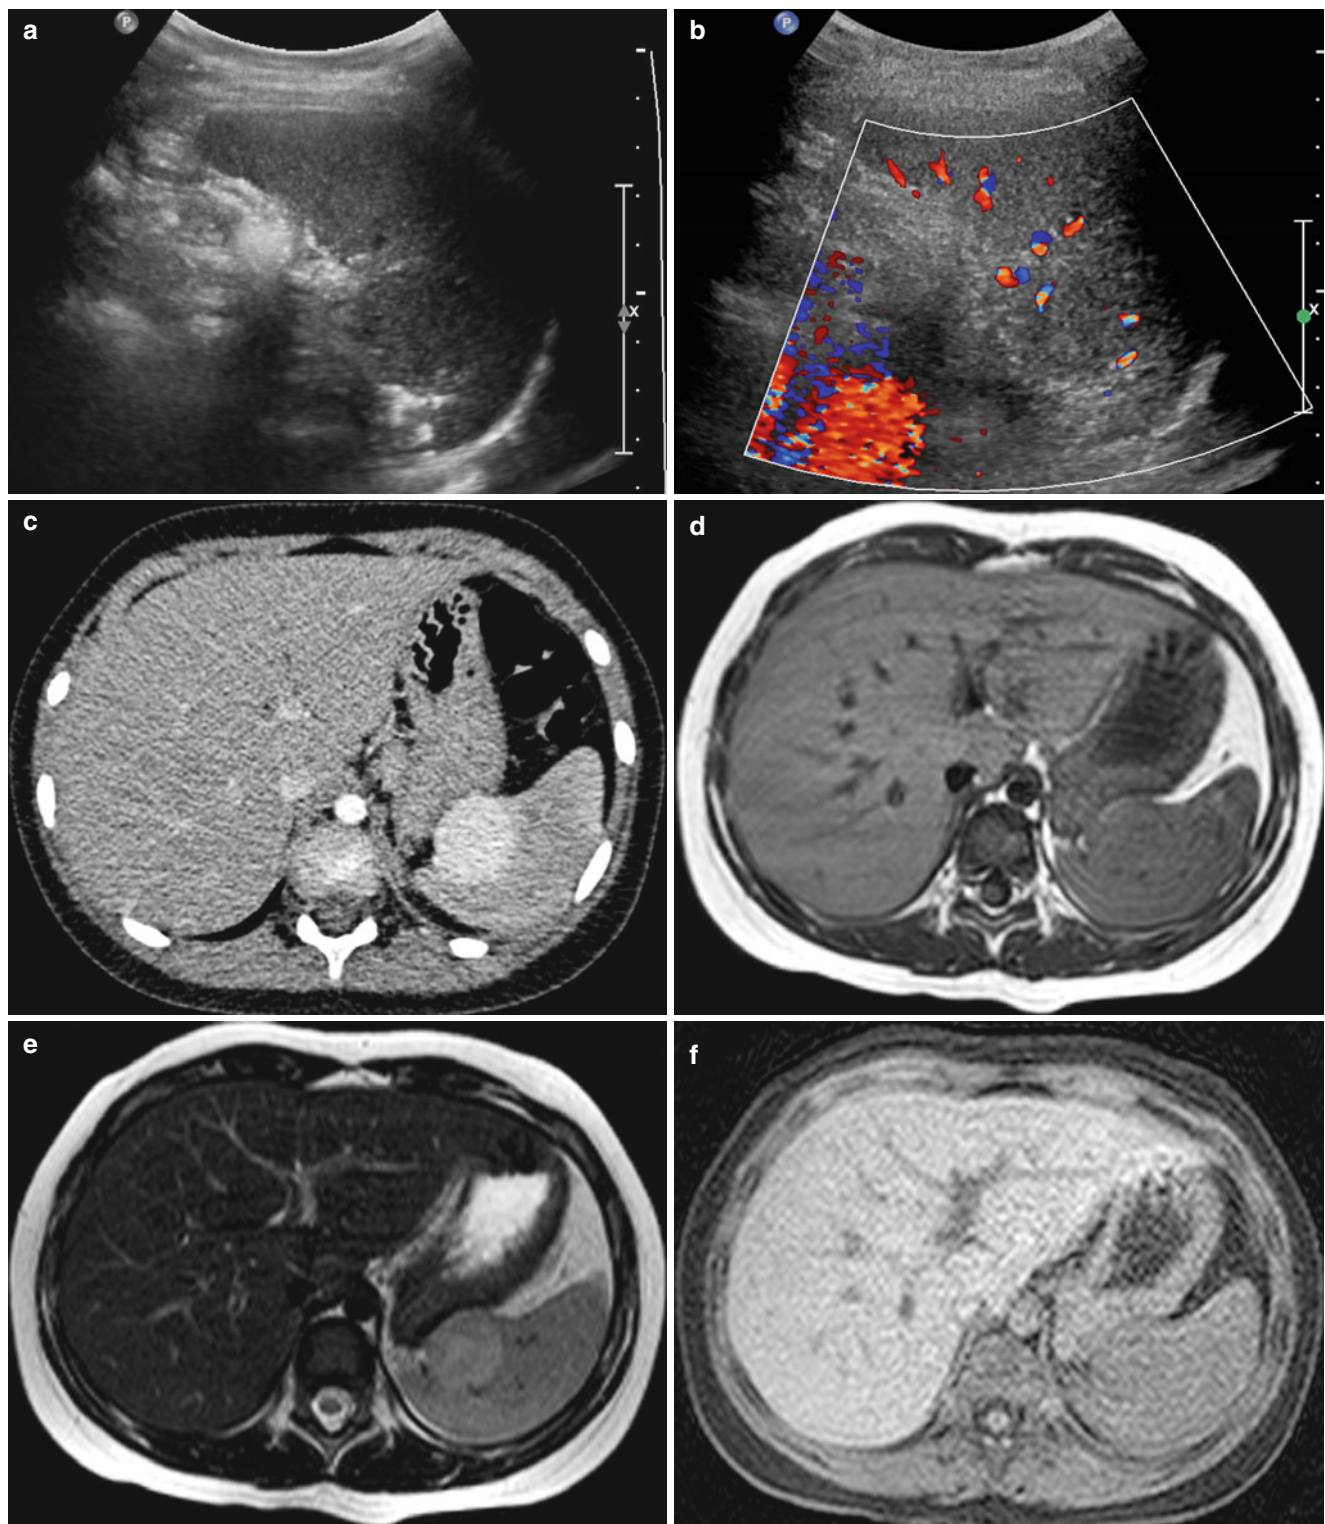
Splenic hamartoma in a 5-year-old boy. (a) Longitudinal US image of spleen shows slightly hypoechoic and exophytic mass. (b) On color Doppler US, the mass shows slightly increased vascularity. (c) Contrast-enhanced abdominal CT shows well-homogenous enhancement of the splenic mass. (d) On T1-weighted image, the splenic mass
